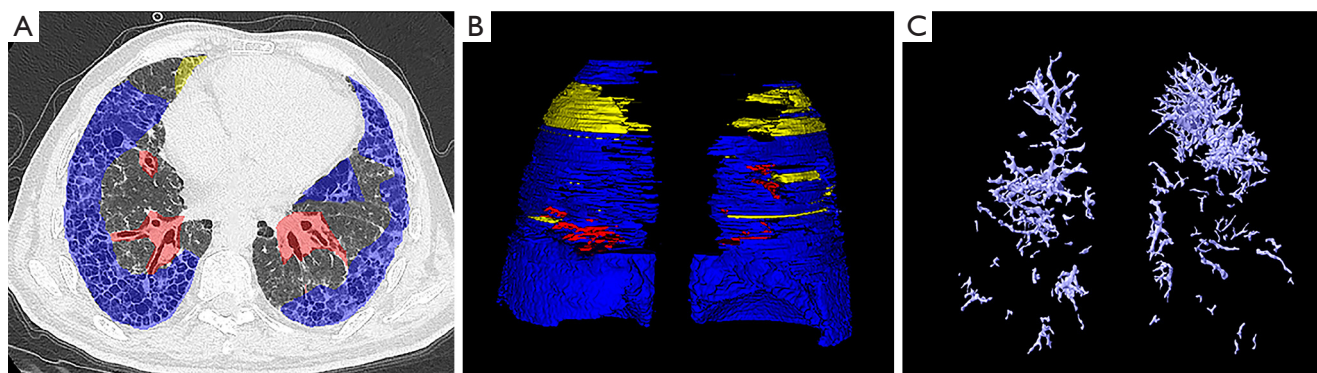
A 62-year-old male patient with IPF who exhibited UIP pattern on HRCT. (A) The 3D visualization of the total pulmonary vasculature with computerized segmentation (34.35 mL); (B) three typical lesion patterns: RE (yellow area), HC (blue area), and TRBR (red area); (C) the total volumes of RE (yellow area), HC (blue area) and TRBR (red area) in this patient were 122.61, 1,360.23, and 9.76 mL, respectively. IPF, idiopathic pulmonary fibrosis; UIP, usual interstitial pneumonia; HRCT, high-resolution computed tomography; TRBR, traction bronchiectasis; RE, reticular pattern; HC, honeycombing; GGO, ground glass opacity.
